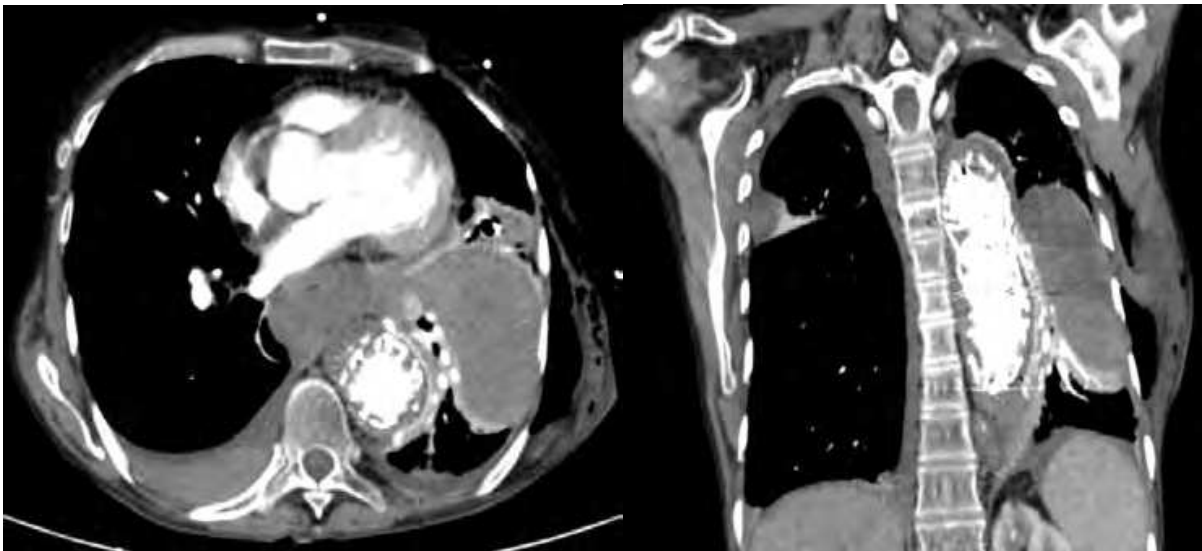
Case 16. Chest computed tomography scan showing a ruptured (contained) pseudoaneurysm in the descending thoracic aorta at the site of a previous thoracic stent graft.
